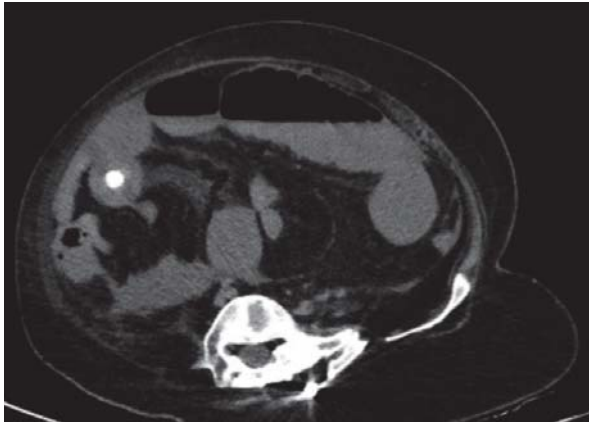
Axial CT scan demonstrating an endoluminal image of a stone measuring approximately 3 cm.
